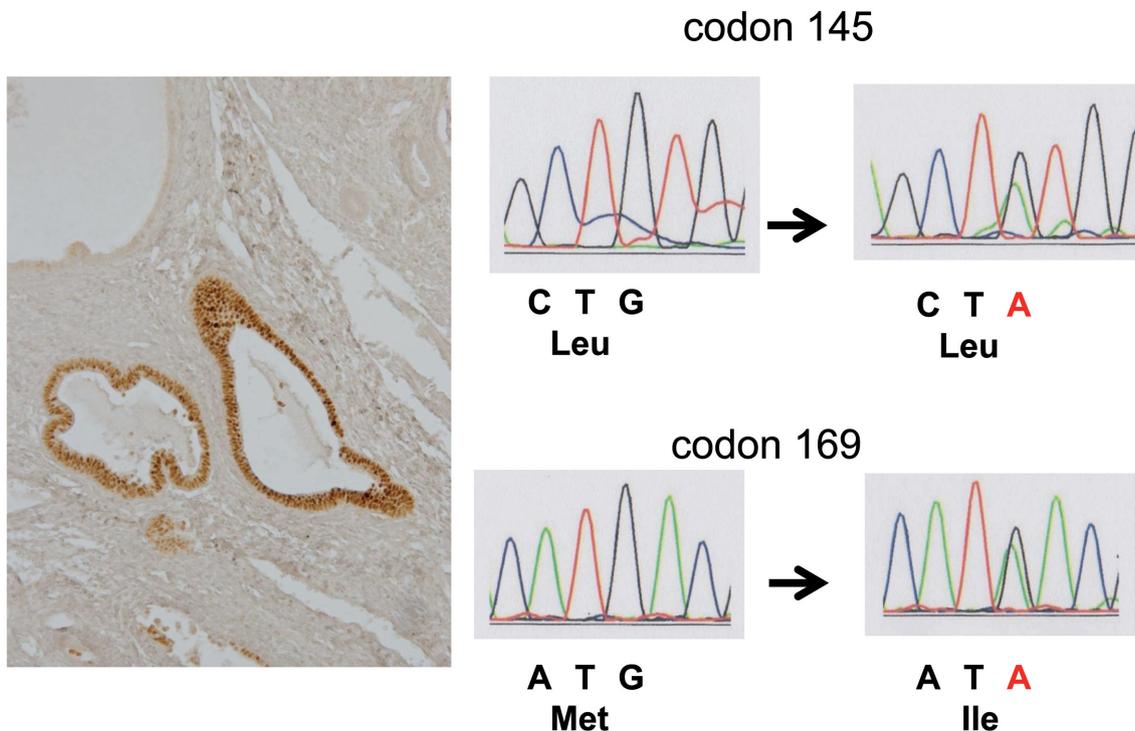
TP53 gene sequencing result from a microdissection sample. Left, The p53 signature. Right, Corresponding DNA sequencing results showing TP53 mutations in exon 5 at codon 145 from CTG to CTA (Leu to Leu) and at codon 165 from ATG to ATA (Met to Ile).
